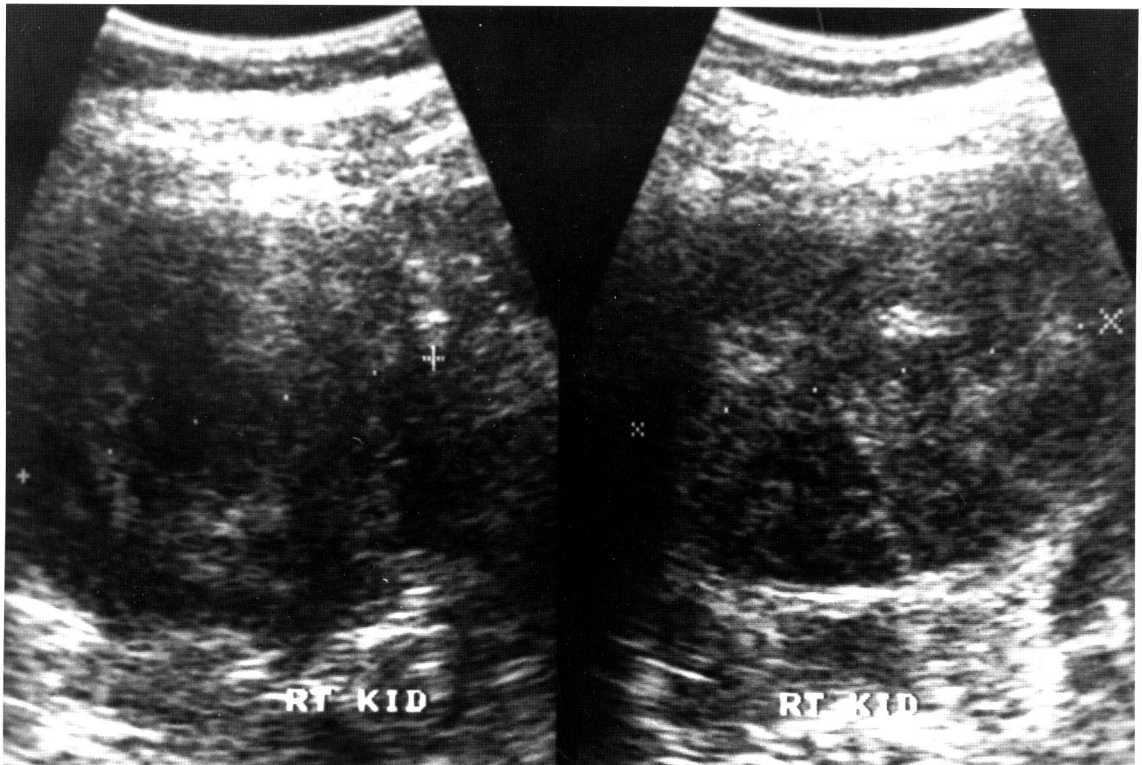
Abdominal ultrasonogram shows an approximately 5 cm sized, round, heterogeneous echoic mass arising from the lateral aspect of the right kidney.
